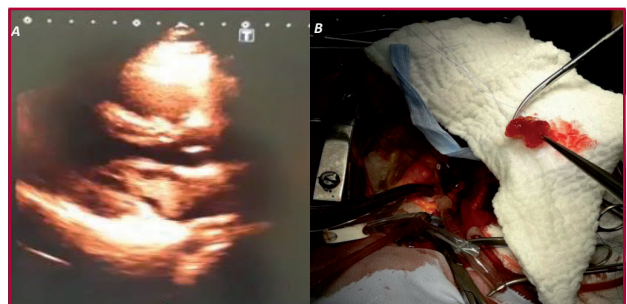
A. Transthoracic echocardiography showing intra-atrial mass suggestive of myxoma. B. Image of surgically removed myxoma.
